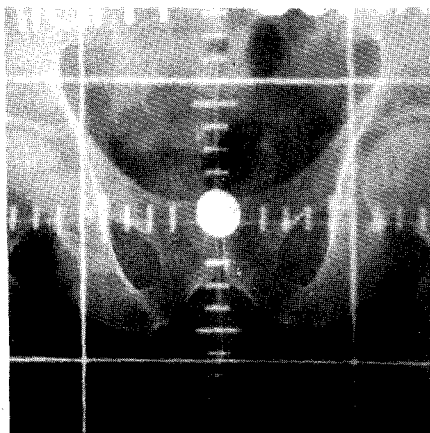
Anterior-posterior radiograph showing treatment volume. Note the mercury-filled Foley catheter which denotes the position of the prostatic urethra.
